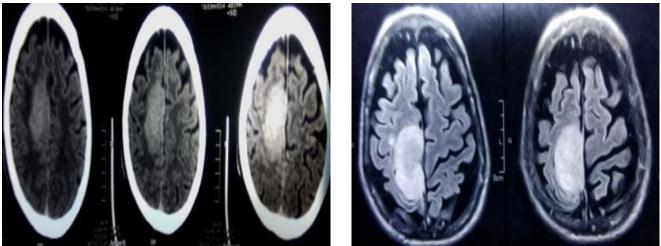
Preoperative axial CT and MRI brain with contrast showing RT falcine extra axial mass mostly meningioma
